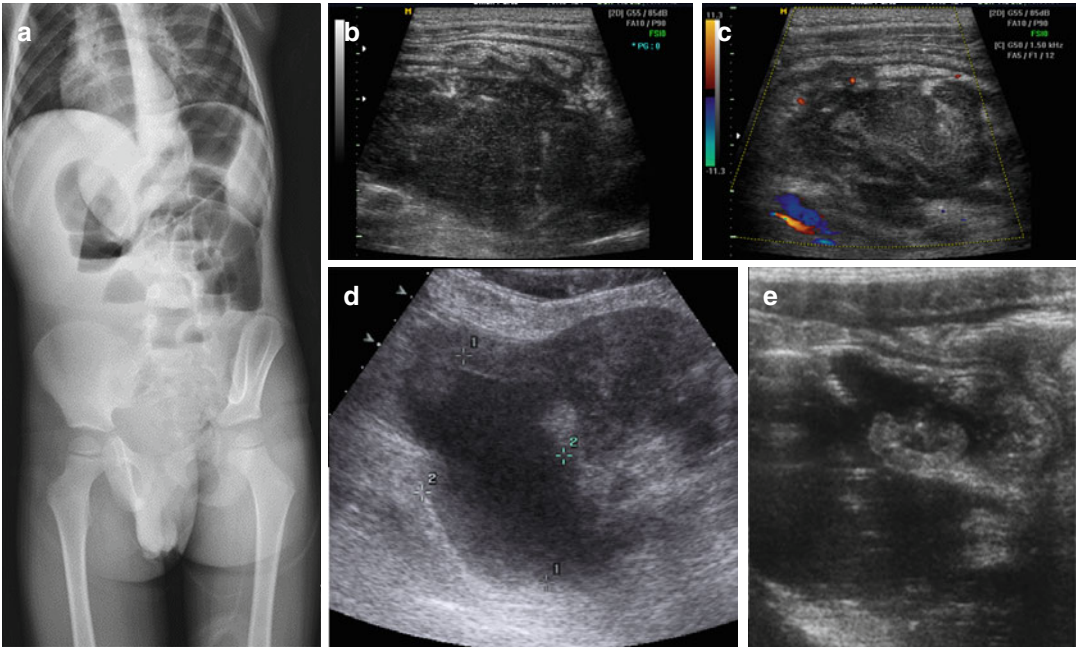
(a) X-ray and (b–e) US scan of abscess; the RX image shows intestinal obstruction with air-fluid levels; the US demonstrates a well-delineated fluid collection with rim enhancement and peripheral wall hyperemia
